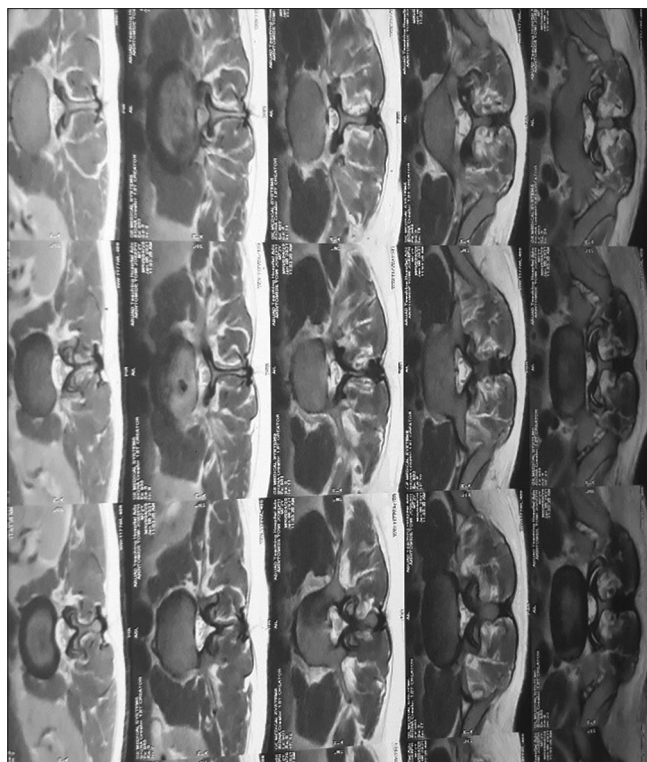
Multilevel magnetic resonance imaging axial cuts of the lumbar region showing varying degrees of disc desiccation
